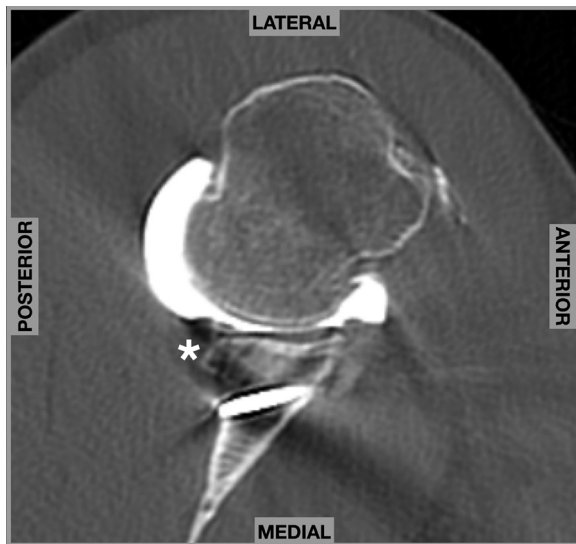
Computed tomography image of a right shoulder in the transverse plane. Note the screw from the prior Latarjet procedure. Asterisk: Area of posterior glenoid bone loss.
